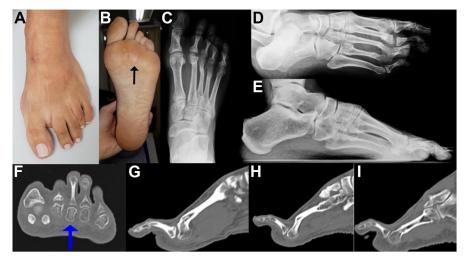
Preoperative evaluation for surgical planning. (*A*) Clinical dorsal view of the foot. (*B*) Clinical plantar view of the foot, with a callosity under the M3 head. Plantar foot pressure point (*black arrow*). (*C*) Weight-bearing anteroposterior radiographic foot view. M2, M3, and M4 with malunion and alteration of the metatarsal formula. (*D*) Weight-bearing oblique radiographic foot view. M2 and M3 severally flexed. (*E*) Weight-bearing lateral radiographic foot view. It is possible to note a misalignment, but it is challenging to identify which metatarsal is deformed. (*F*) Coronal computed tomography view. The arrow marks the M3 head flexed, changing the metatarsals heads relation. (*G*) M2 sagittal computed tomography view. The location and quantification of the deformity, (*H*) M3 sagittal computed tomography view. Te location and quantification of the deformity. (*I*) M4 sagittal computed tomography view. One should note that there is no M4 malunion.
